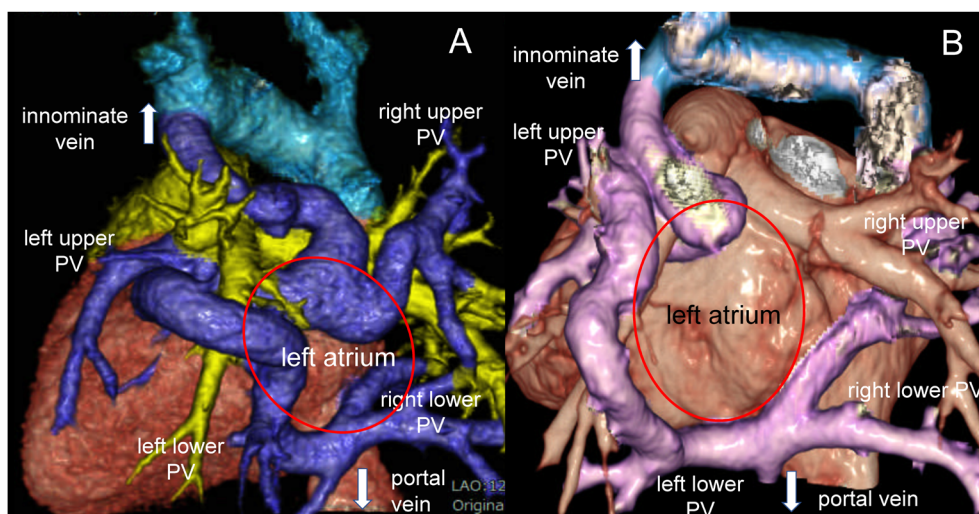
Cardiac computed tomography shows pulmonary veins form chambers encircling left atrium (red circle) which drain into innominate vein and portal vein in Case1 (A), in Case 2 (B)
